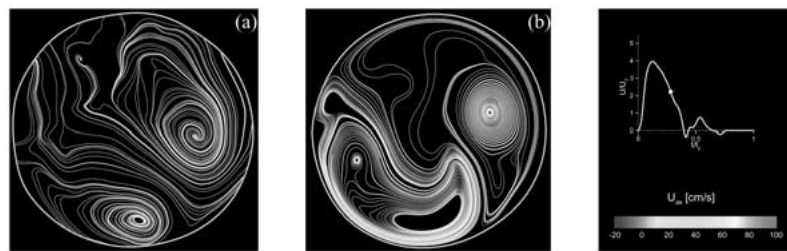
Healthy configuration: streamlines at cross-section F during systolic deceleration color-coded with the velocity magnitude; comparison between MRI measurement (a) and CFD result (b).
